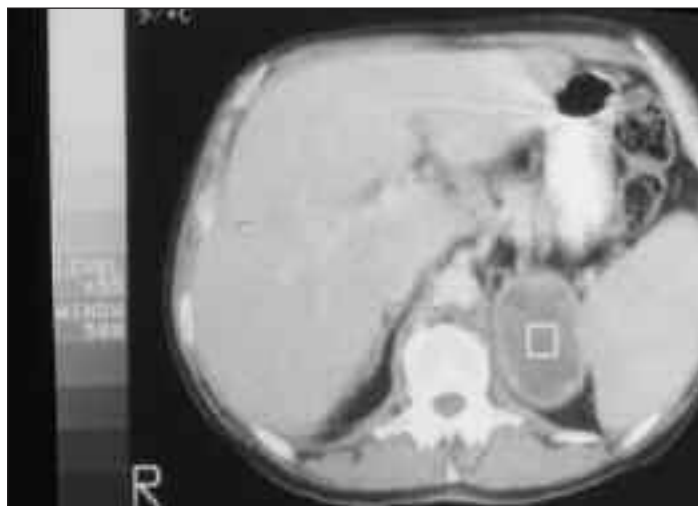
CT scan shows hepatosplenomegaly and an enlarged adrenal gland. Image provided by Dr. Carol Kauffman and used with permission.
